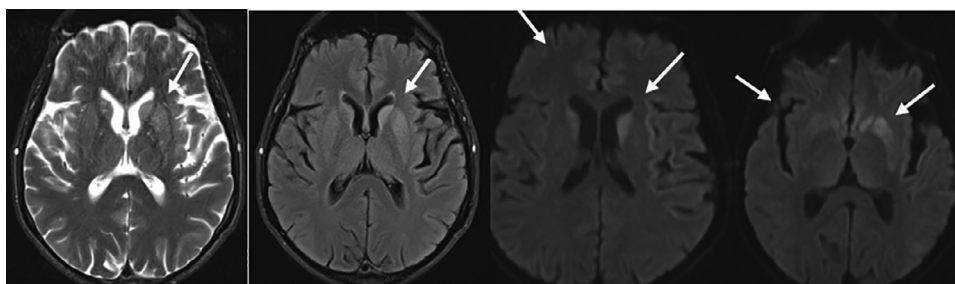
Axial T2-weighted, FLAIR, and Diffusion sequences: Hyperintense signal anomalies on FLAIR and T2 sequences with diffusion restriction involving the left parasagittal and paracentral frontal regions, the motor and premotor areas, the basal ganglia, and the bilateral temporal and insular cortical ribbon, with a more pronounced involvement on the left side.
